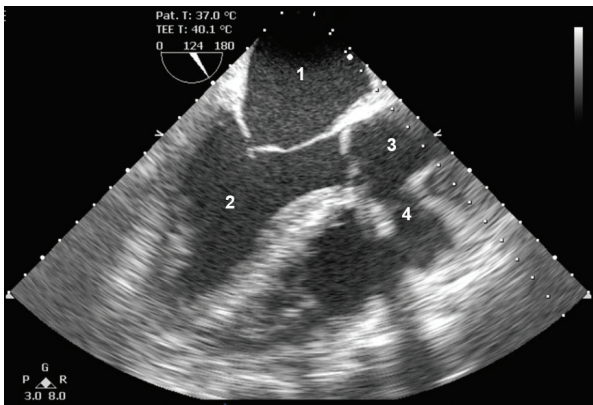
Two-dimensional transoesophageal echocardiogram in long-axis view. 1, left atrium; 2, left ventricle; 3, aorta; 4, origin of tunnel. The origin of the tunnel arises from the proximal ascending aorta.
